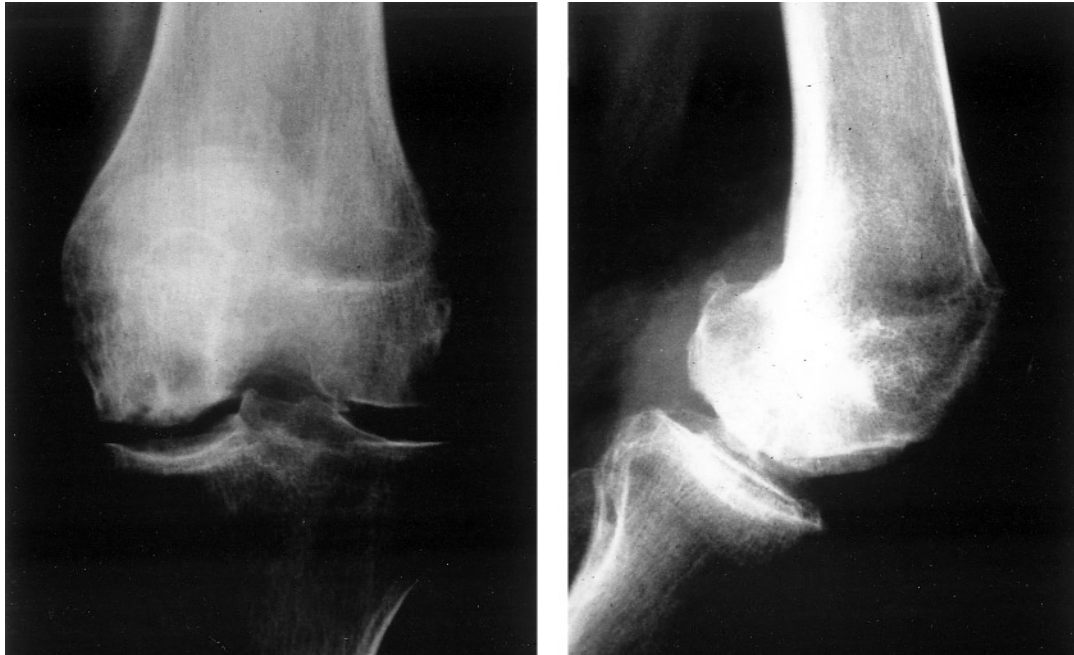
Radiographs of knee joint from a 35-year-old woman show a small osteolytic lesion after multiple arthroscopic and open synovectomies. She is free of PVS but the joint shows the typical postarthritic destruction pattern.
